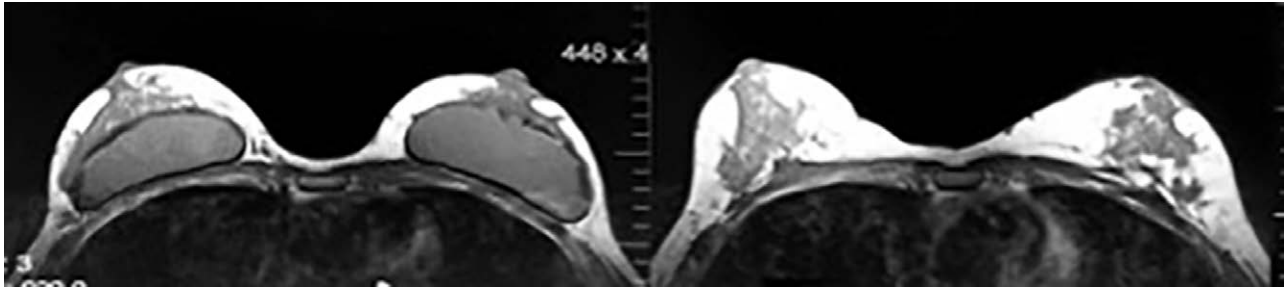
(Left) Preoperative magnetic resonance imaging scan of the patient in Figure 10. (Right) One-year postoperative magnetic resonance imaging scan shows replacement of the implant with normal appearing fat.
